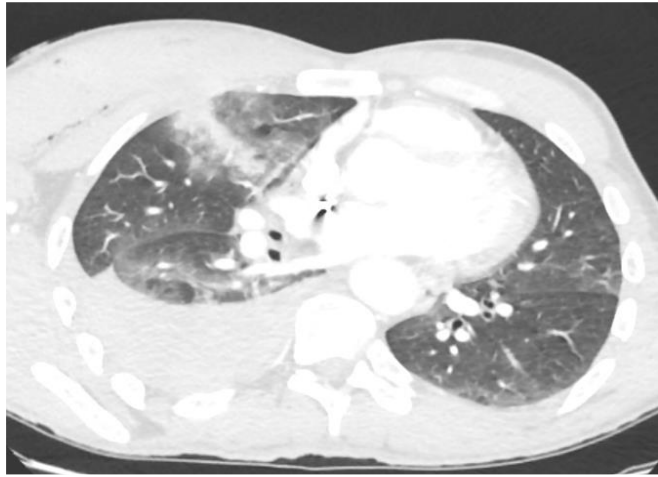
Spiral CT angiography of pulmonary arteries: a metal fragment in the wall of the left atrium. A – axial plane; B – coronal plane; B – sagittal plane.
